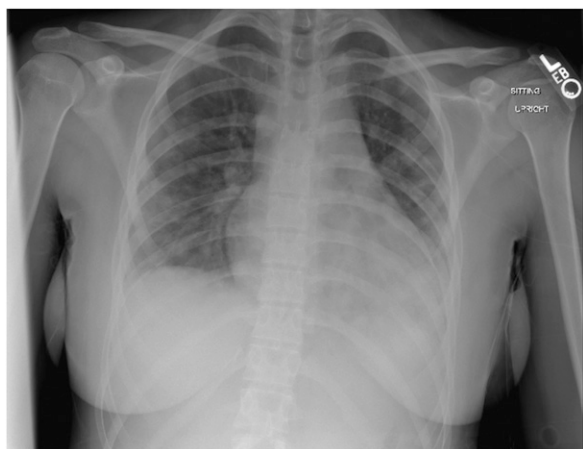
Patient's chest radiograph.
